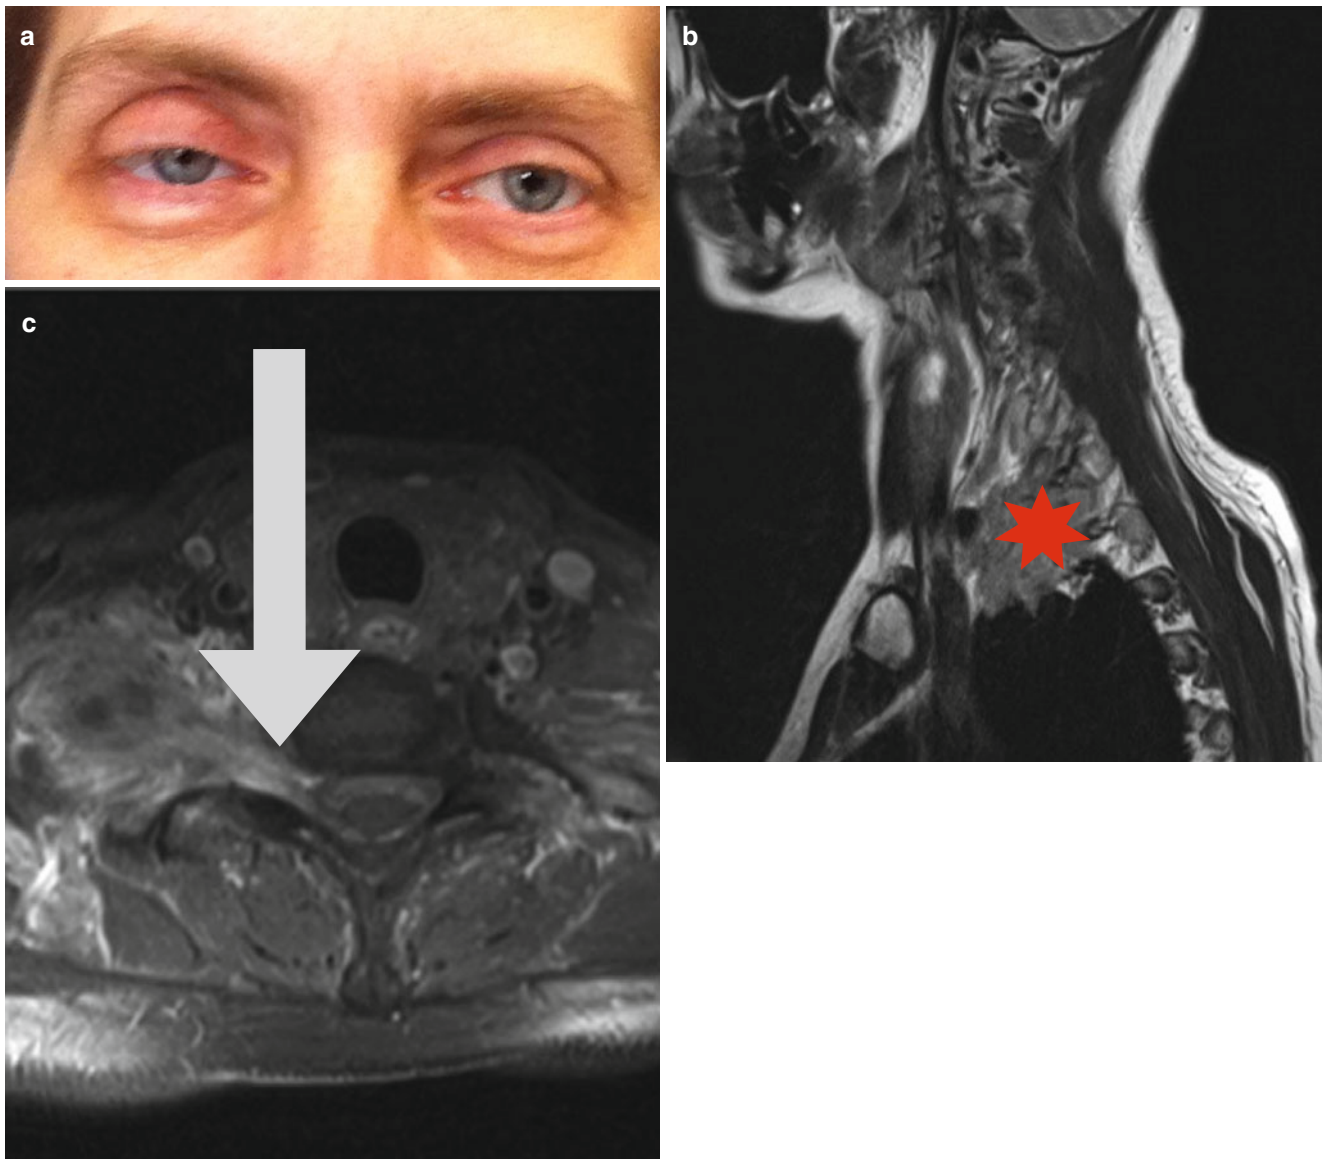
Pancoast tumor. Some characteristics of Pancoast tumors. (a) Horner's syndrome, (b) apical lung tumor (*asterisk*), (c) nerve root infiltration by tumor seen in MRI (*arrow*)
